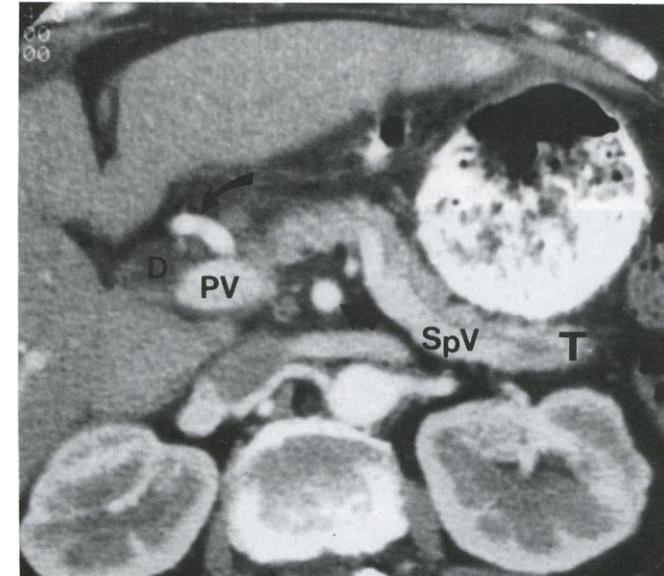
CT of normal pancreas. The pancreatic body and tail (T) are well seen in their usual retrogastric location. Contrast enhancement is noted in the normal splenic vein (SpV), portal vein (PV), and superior mesenteric artery (arrow). The hepatic artery (curved arrow) is arching anterior over the bile duct (D).
